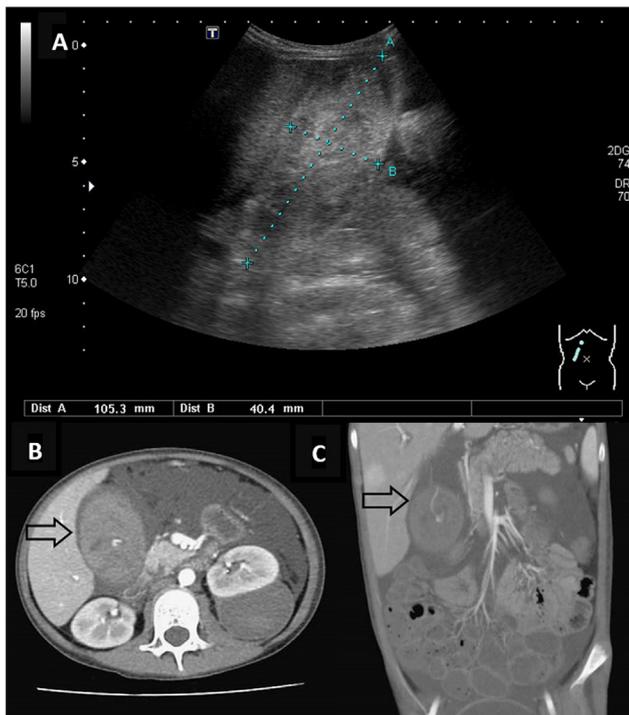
The images of gallbladder bleeding. (A) Sonography showed distended gallbladder with heterogeneous echogenic material. (B, C) Computed tomography (CT) showed active gallbladder luminal hemorrhage with the arrows pointing active contrast medium extravasation into gallbladder lumen.
